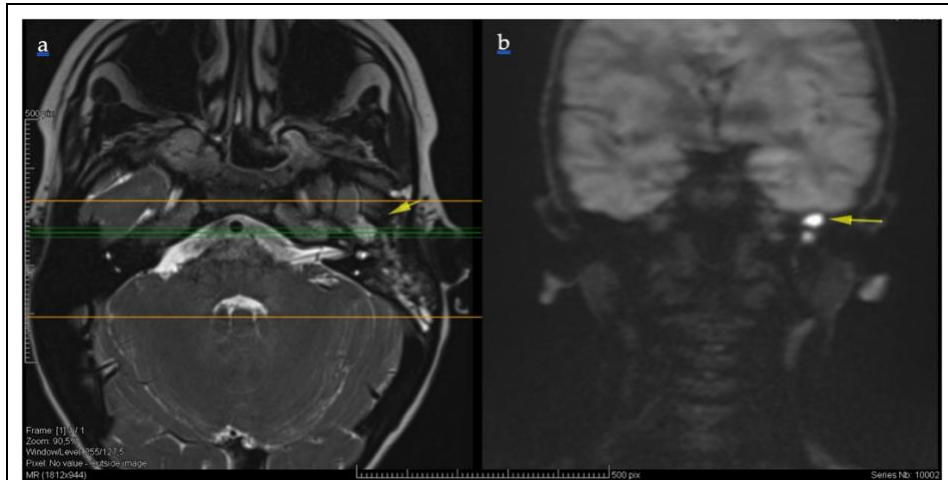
(AB): T2 (a) & Diffusion (b): Weighted magnetic resonance imaging revealing a focal diffusion restriction in the left middle ear (yellow arrow).
